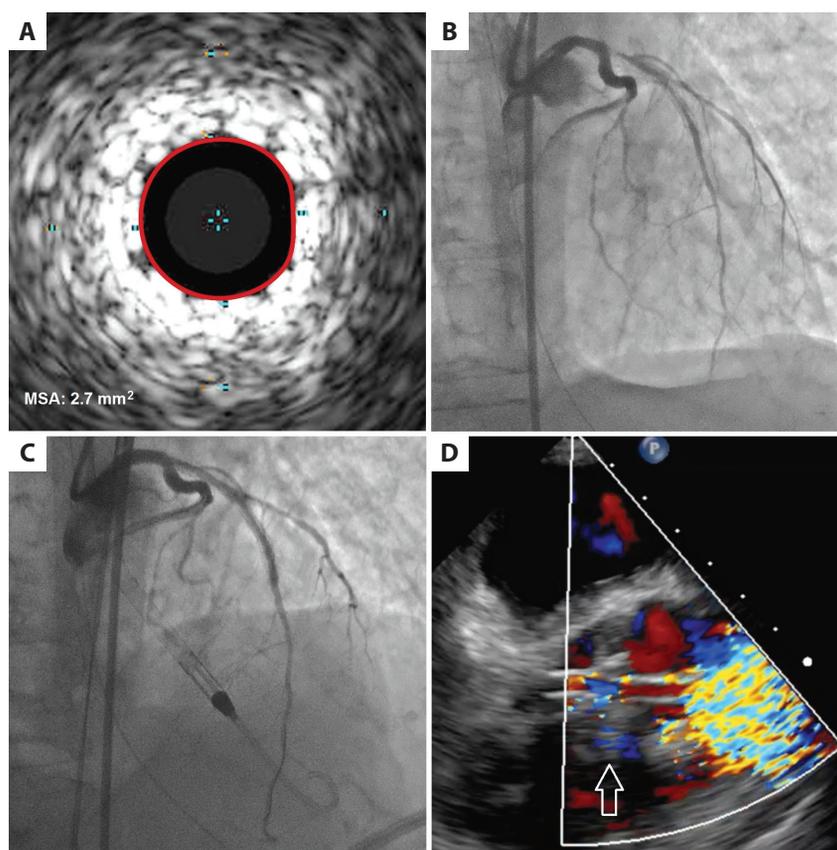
Impella CP during revascularization in cardiogenic shock. A. Intravascular ultrasound image shows 2 layers of under-expanded stents within the calcified circular lesion in the left anterior descending artery (LAD); the minimal stent area (MSA) is 2.7 mm². B. Left coronary angiography presents critical thrombotic lesions in the LAD and distal chronic occlusion of the circumflex artery. C. Effect of the balloon angioplasty of the LAD with the Impella support. D. Transesophageal echocardiography during cardiac surgery shows a proper position of the Impella pump (see Supplementary material, *Video S1*): the biggest colored "storm" (i.e. the blood flow from the outlet) is above the aortic valve (the arrow indicates aortic cusps)
